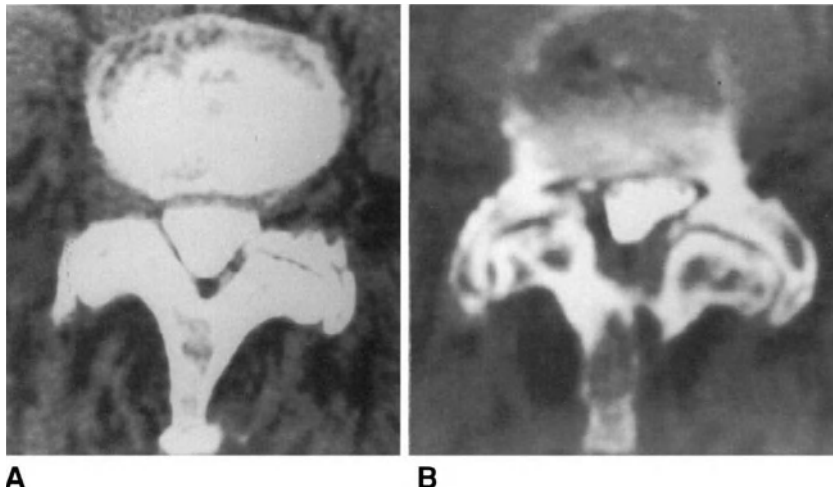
Myelo-CT scans in a patient with nerve-root canal stenosis at L4-L5 level on the right. (A) Section obtained proximally to the disc. (B) Section at the level of the proximal vertebral end-plate of L5. The L5 nerve root is not visible.
